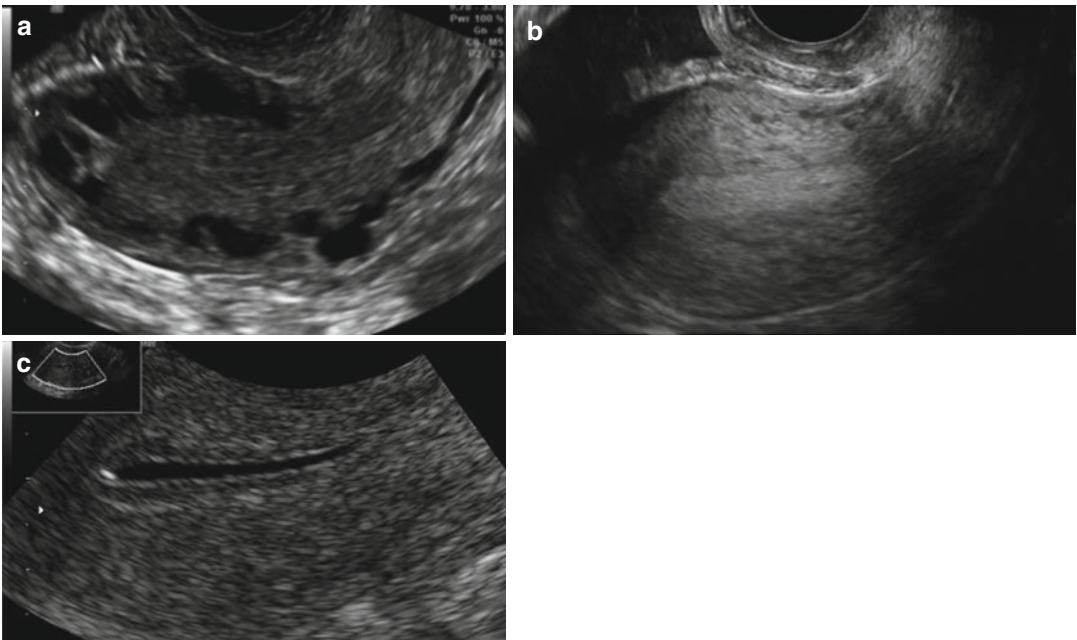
The endometrial line needs to be visible for optimal ultrasound imaging. 2D sagittal image of the uterus: (a) the endometrium is not visible. (b) a well-defined
